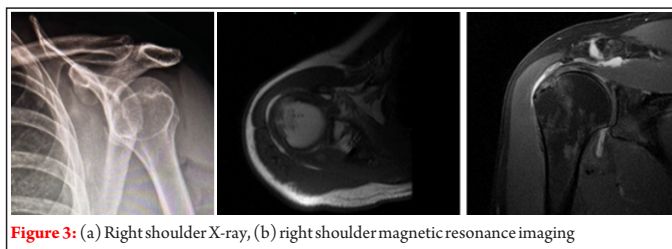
(a) Right shoulder X-ray, (b) right shoulder magnetic resonance imaging
